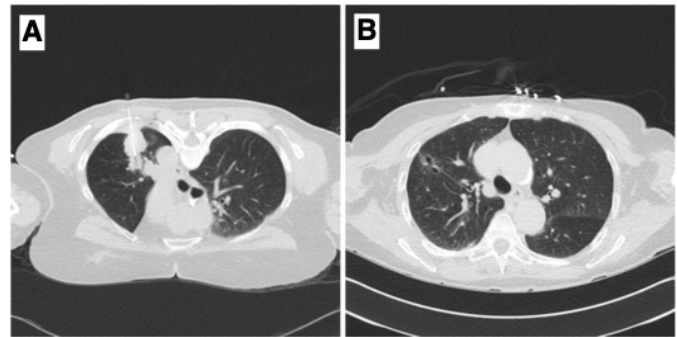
Example CT images from provided dataset demonstrating (A) a needle-containing image and (B) an image lacking a needle.
